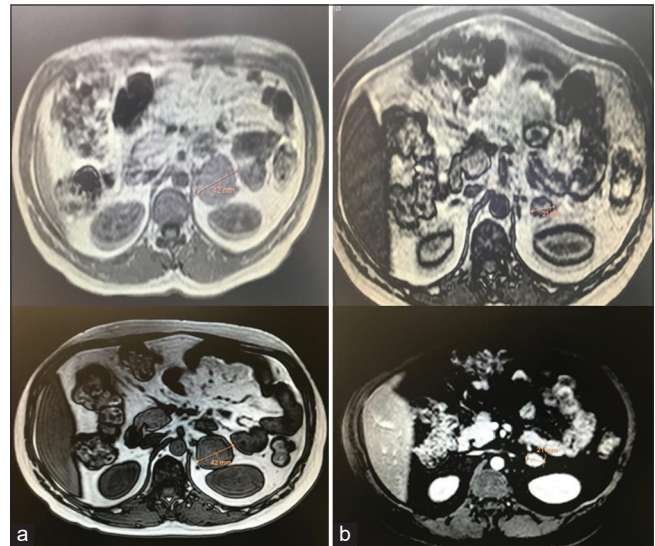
Adrenal mass in left adrenal gland in MRI scan, (a) before the treatment. (b) After the treatment
